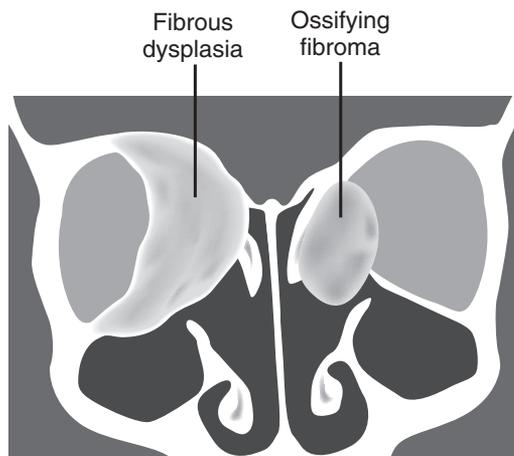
Characteristics of fibrous dysplasia (FD) and ossifying fibroma (OF) that aid in differentiating the 2 on CT. Fibrous dysplasia tends to have ground glass appearance of involved bone with blended borders with surrounding uninvolved bone whereas OF is a well-circumscribed lesion with an irregular, sclerotic border. OF tend to be round or ovoid in shape as well due to their neoplastic expansion from a single focus.
